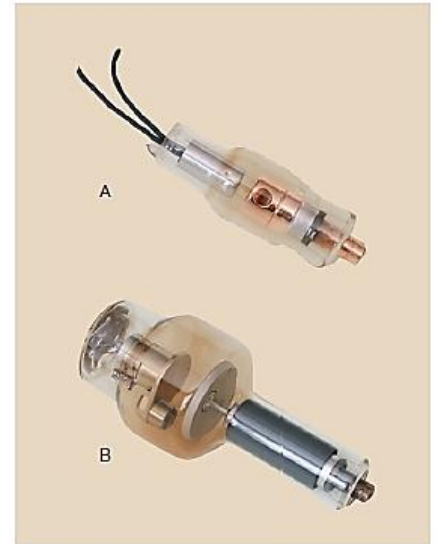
All diagnostic x-ray tubes can be classified according to the type of anode. A, Stationary anode. B, Rotating anode.
